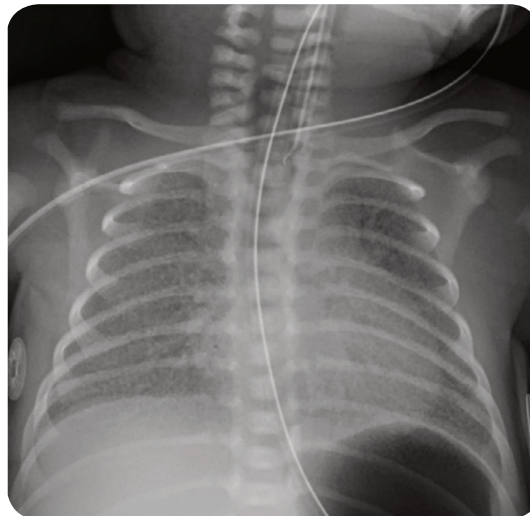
A plain chest radiograph of a neonate with infant respiratory distress syndrome. Both lung fields are granular in appearance.
